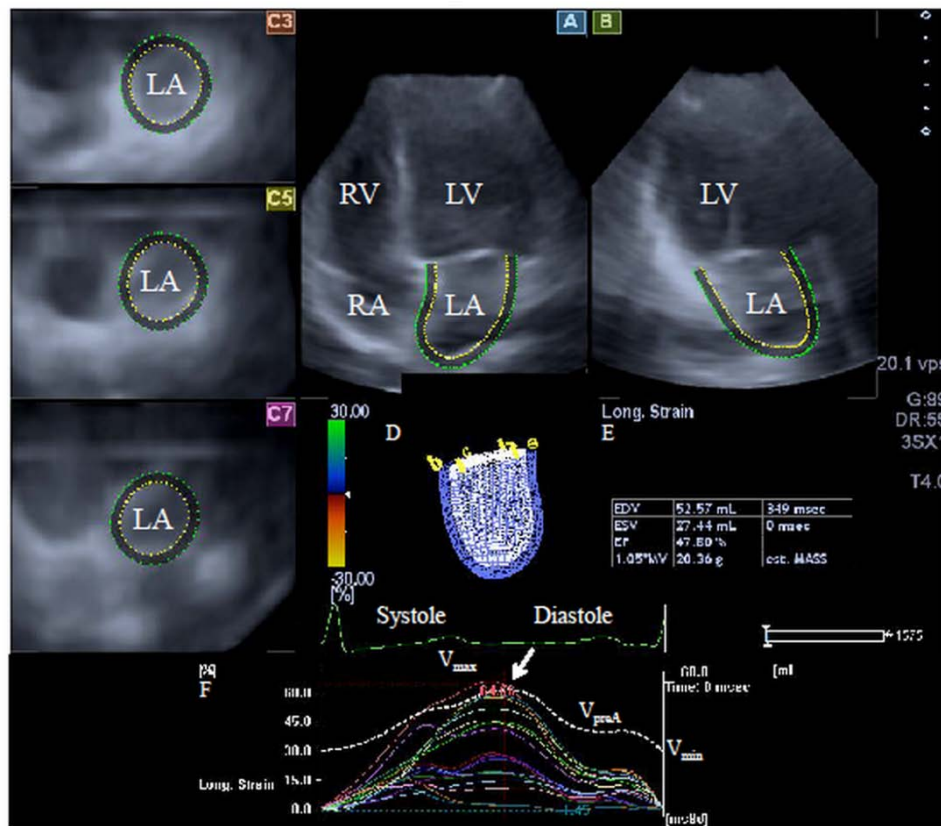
Images from three-dimensional (3D) full-volume dataset showing left atrium (LA) in a patient with type 1 diabetes mellitus is presented: (A) apical four-chamber view, (B) apical two-chamber view, (C3) short-axis view at basal, (C5) mid- and (C7) superior left atrial level. A 3D cast (D), volumetric data (E), time – global volume and time – segmental strain curves (F) of the LA are also presented. Dashed curve (F) represents LA volume changes during cardiac cycle with maximum (V_{max}), minimum (V_{min}) LA volumes and LA volume before atrial contraction (V_{preA}). White arrow represent peak strain (F).
